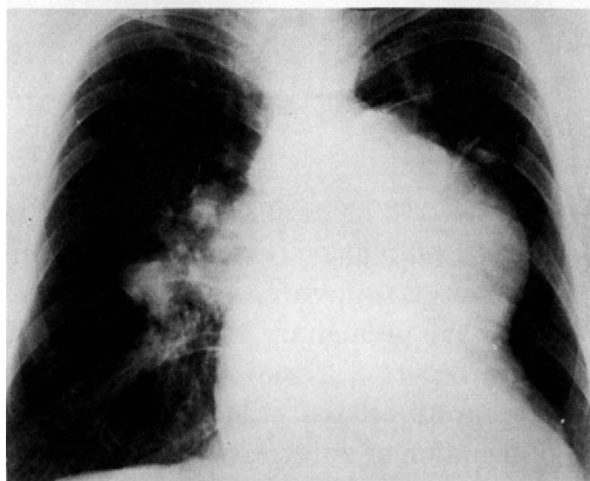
In 1984 chest X-ray demonstrated massive pulmonary trunk enlargement and peripheral oligemia.
